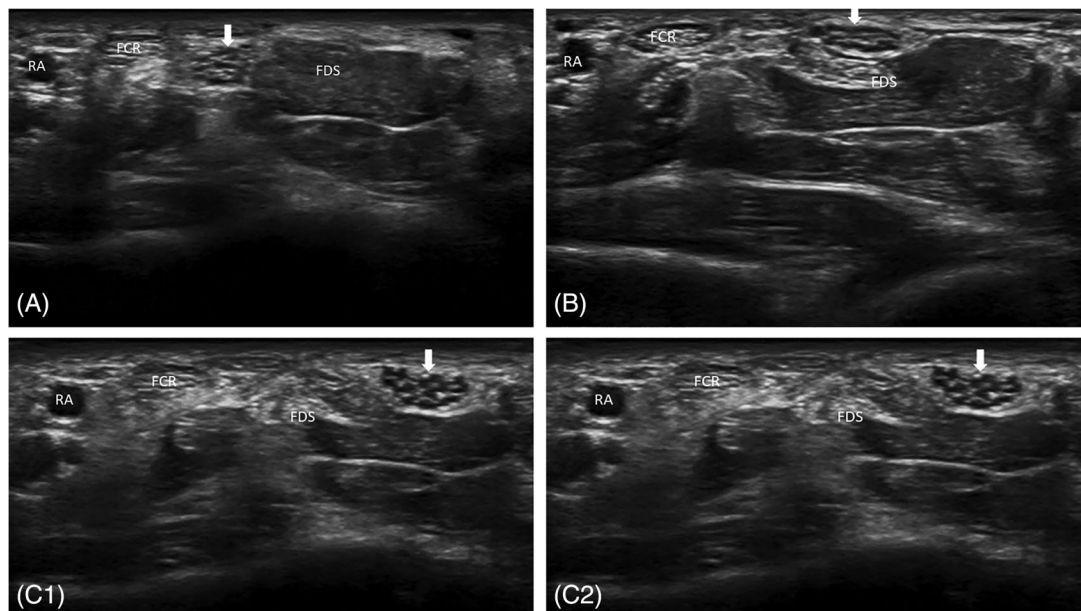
Axial sonograms show, during wrist flexion, the median nerve (arrow) dislocates, radial to ulnar, with respect to the flexor digitorum superficialis muscle and tendons (FDS) (A–C). FCR, flexor carpi radialis; RA, radial artery
